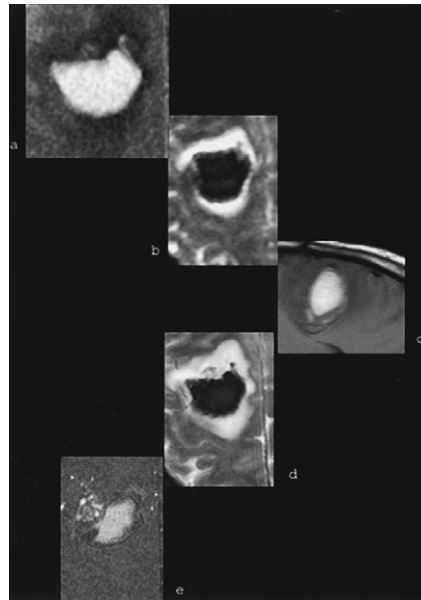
(a) Acute hematoma on CT. On follow-up MRI, the markedly decreased signal on the diffusion-weighted (b) and T2-weighted (d) images and the increased signal on the T1-weighted image (c) are secondary to intracellular methemoglobin. Individual partition from a Magnetic Resonance Angiography (MRA) uncovers the underlying arteriovenous malformation.
